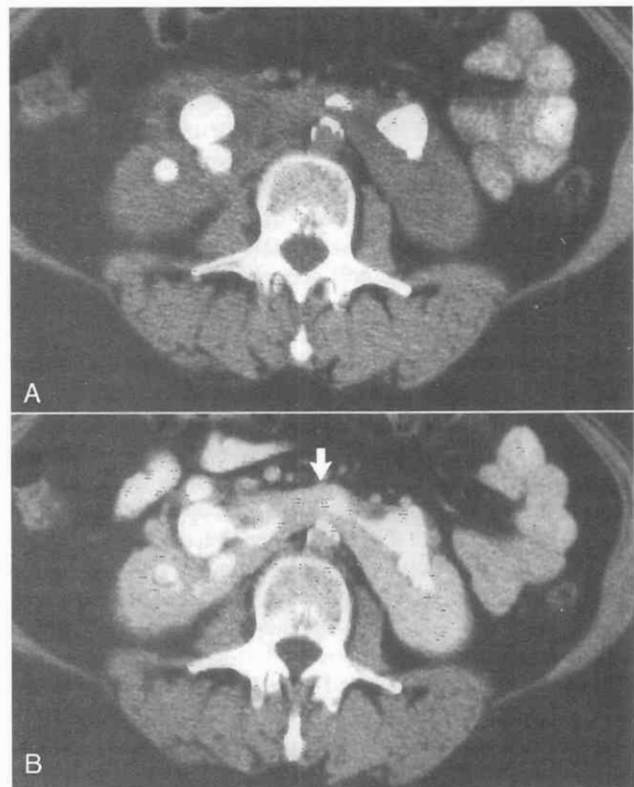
Horseshoe kidney. *A*, Unenhanced scan shows staghorn calculi involving both elements of a horseshoe kidney. *B*, Contrast-enhanced CT scan shows malrotation of both kidneys with the renal pelvises directed anteriorly. The kidneys are joined by an isthmus (*arrow*) of functioning renal parenchyma.
